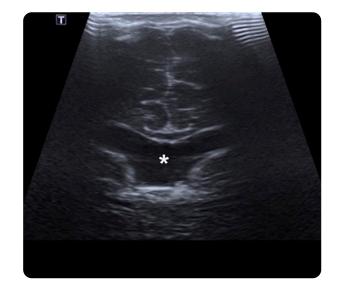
2-month-old male patient with a diagnosis of unspecified seizure syndrome. Coronal transfontanelar ultrasonography: absence of the pellucid septum.
